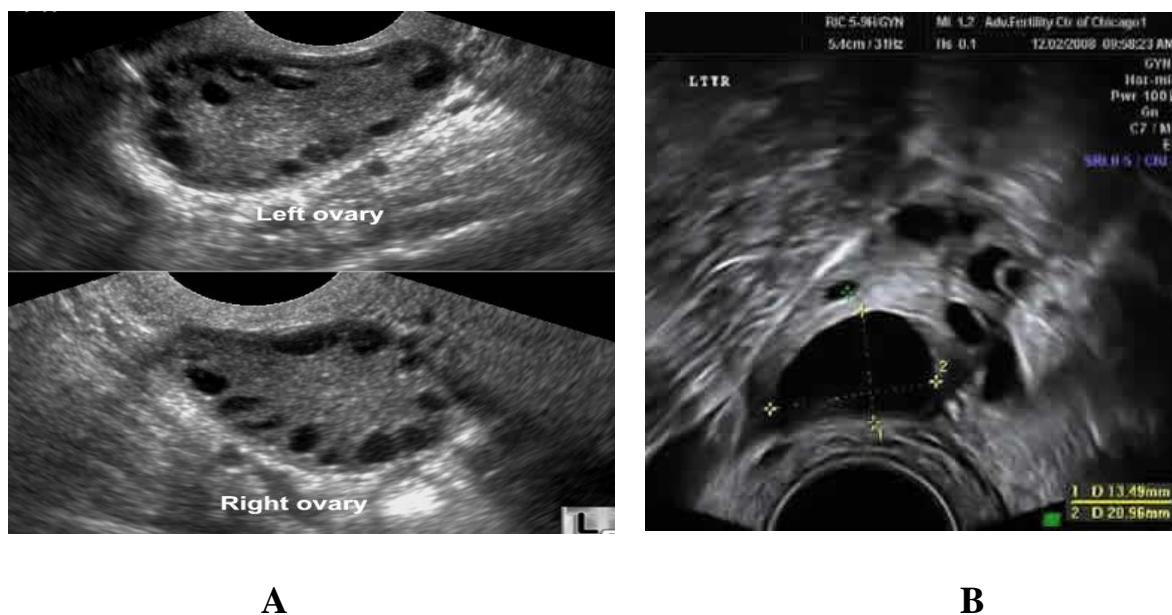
Ovarian ultrasound
